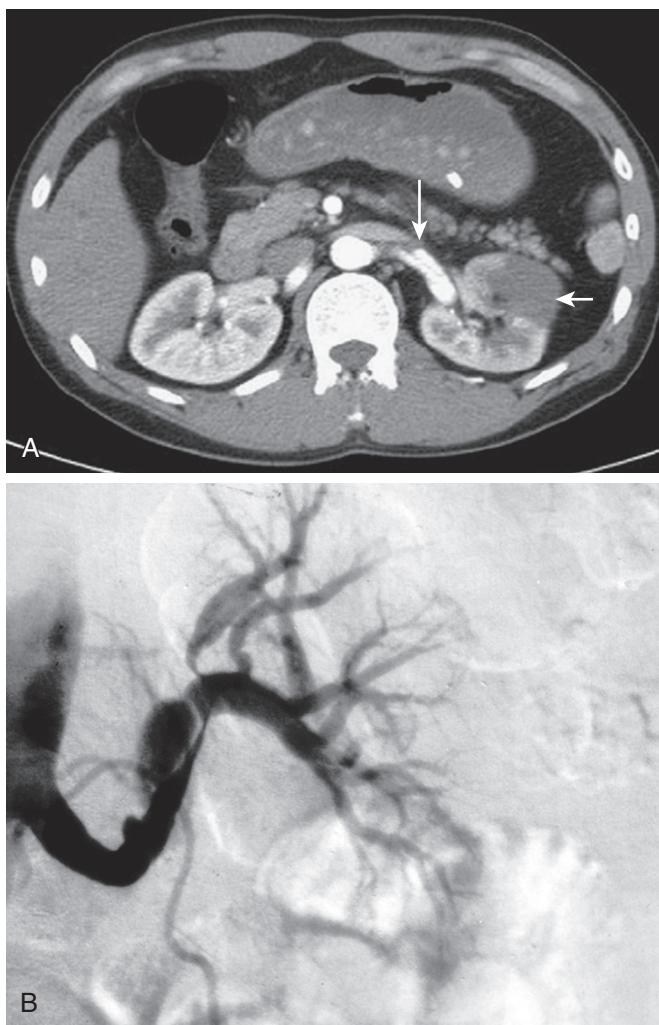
Spontaneous Renal Artery Dissection. (A) Axial computed tomography angiographic image shows left renal artery dissection (long arrow) with ipsilateral upper pole renal infarction (short arrow). (B) Contrast angiogram demonstrating spontaneous renal artery dissection extending into the hilar branches of the left kidney. (A, From Tsai TH, Su JT, Chao CC et al. Spontaneous renal artery dissection complicating with renal infarction. *Urology*. 2010;76:1371–1372. B, From van Rooden CJ, van Baalen JM, van Bockel JH. Spontaneous dissection of renal artery: long-term results of extracorporeal reconstruction and autotransplantation. *J Vasc Surg*. 2003;38(1):116–122.)
